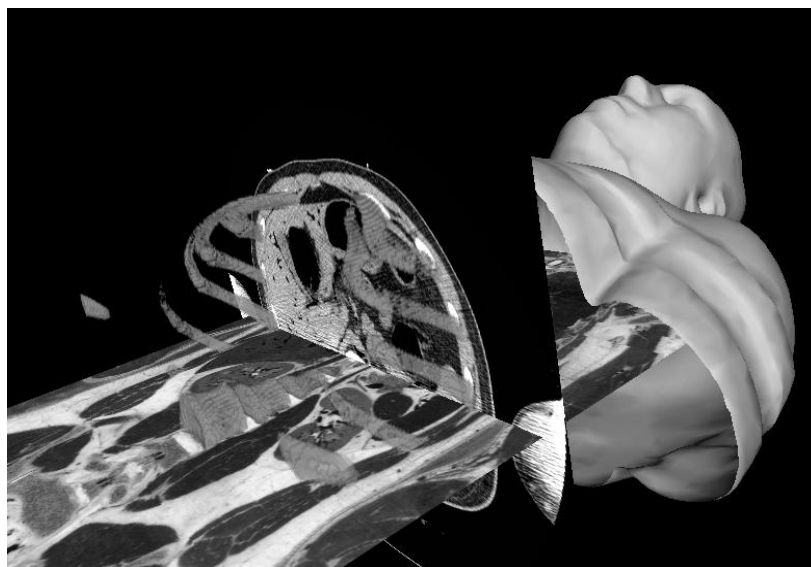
Understanding the principles of medical imaging: The virtual scene shows one photographic slice image (coronal) together with a CT slice (transverse). In addition, 3d models of bone structures and skin are visualized.
